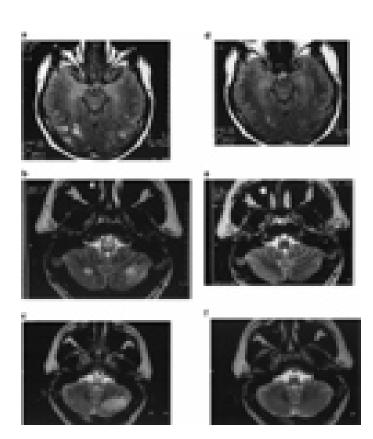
Brain MRI of patient
